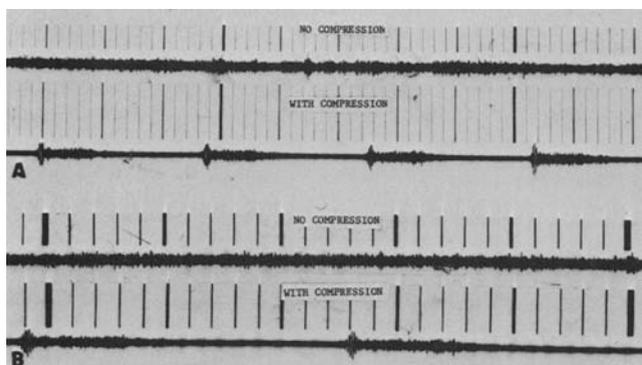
Doppler ultrasound tracing of superior sagittal sinus flow measured at the anterior fontanelle. With anteroposterior pressure exerted on the forehead, a marked reduction in blood flow is noted.
